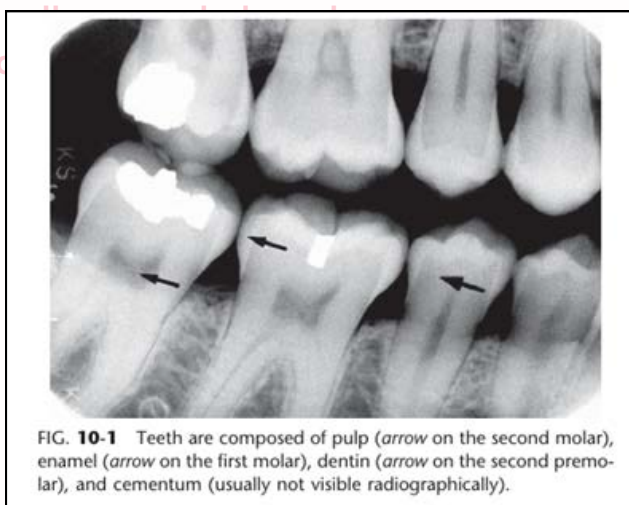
Teeth are composed of pulp (arrow on the second molar), enamel (arrow on the first molar), dentin (arrow on the second premolar), and cementum (usually not visible radiographically).
